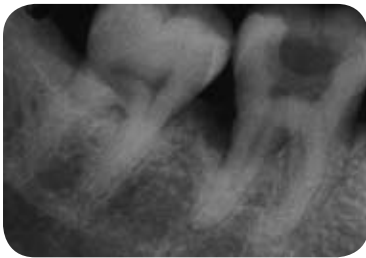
Vertical bone defect on the mesial and distal of No. 20, possibly associated with heavy occlusal load as a result of the absence of molar occlusion. (Radiograph courtesy of Dr. Shaziya Haque.)
